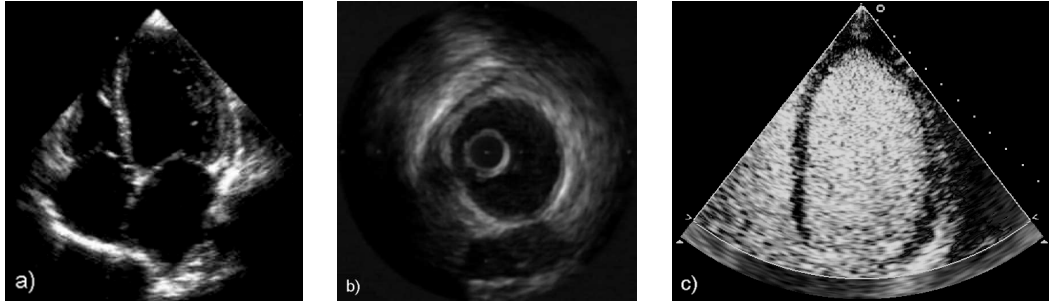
a) Echocardiography. Long axis view of the heart. b) IVUS section showing inner vessel morphology. c) Contrast echocardiography showing myocardium perfusion.
